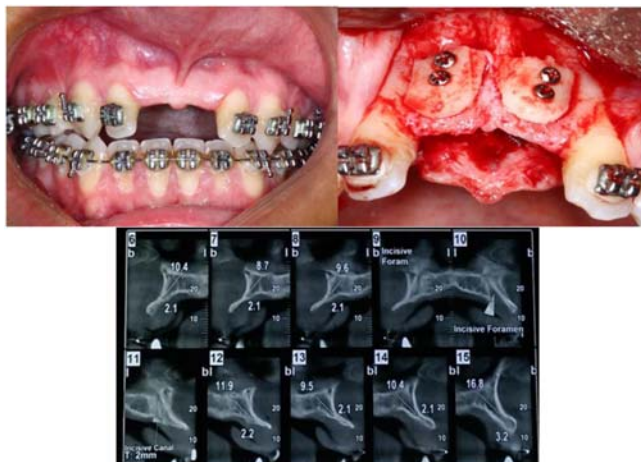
Onlay bone grafting and preoperative CBCT of the defect.
